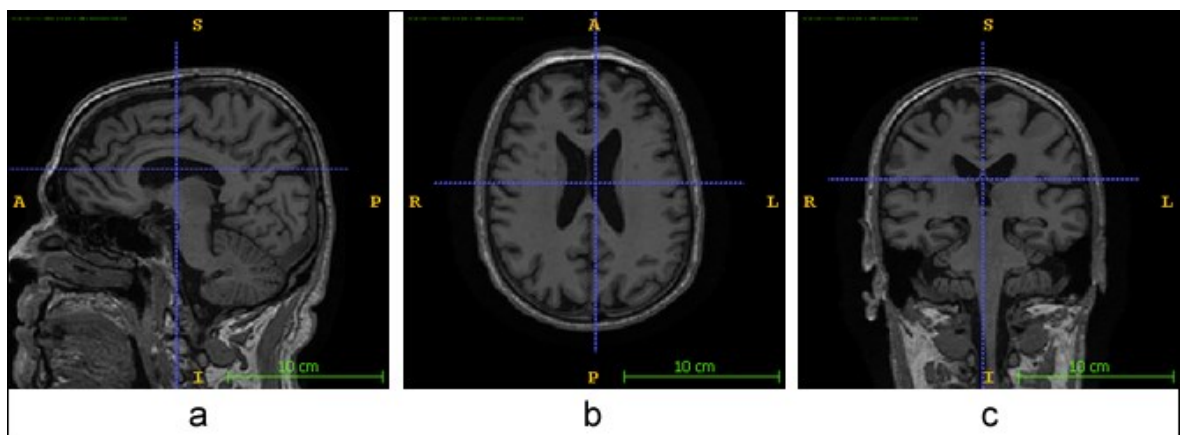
View of Sagittal (a), Axial (b) and Coronal (c) plane of the brain MRI
